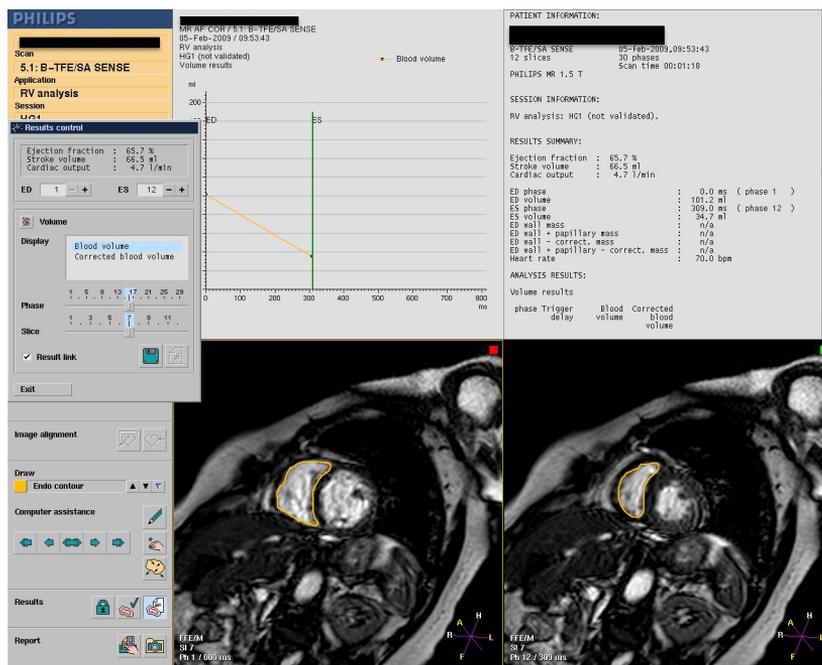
Example of RVEF estimation by MRI. Scan was performed using a b-TFE sequence as described in the main text. The right ventricular volume of each slice and phase was drawn by hand, and calculated by summation.
